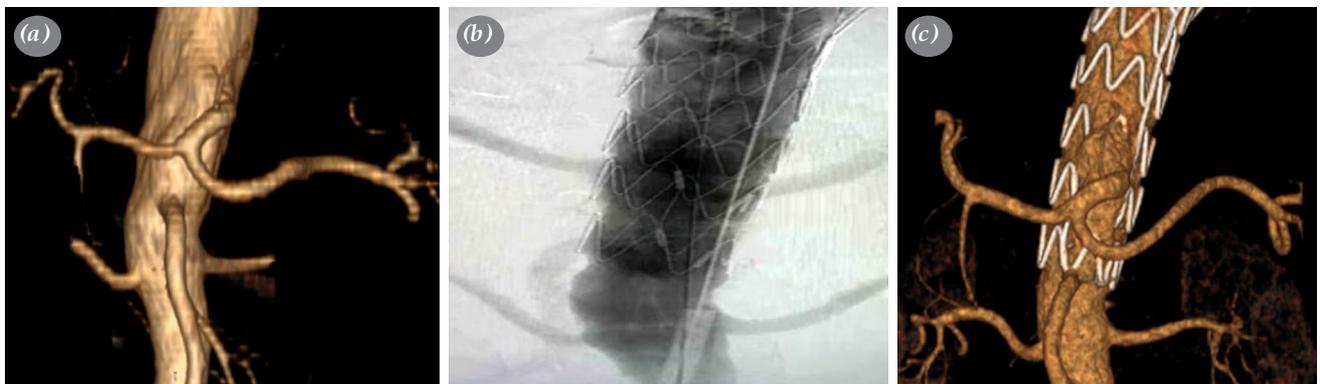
(a) Preprocedural CTA, (b) The completion angiography, (c) Postoperative first-month CTA showing no endoleak and orientation of the fenestration and the ostium of the celiac truncus.
